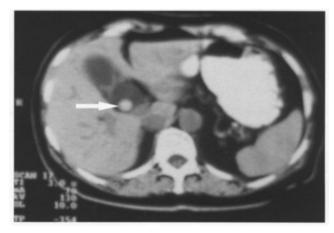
CT of upper abdomen. Distension of Common bile duct. The arrow depicts a stone in CBD.
